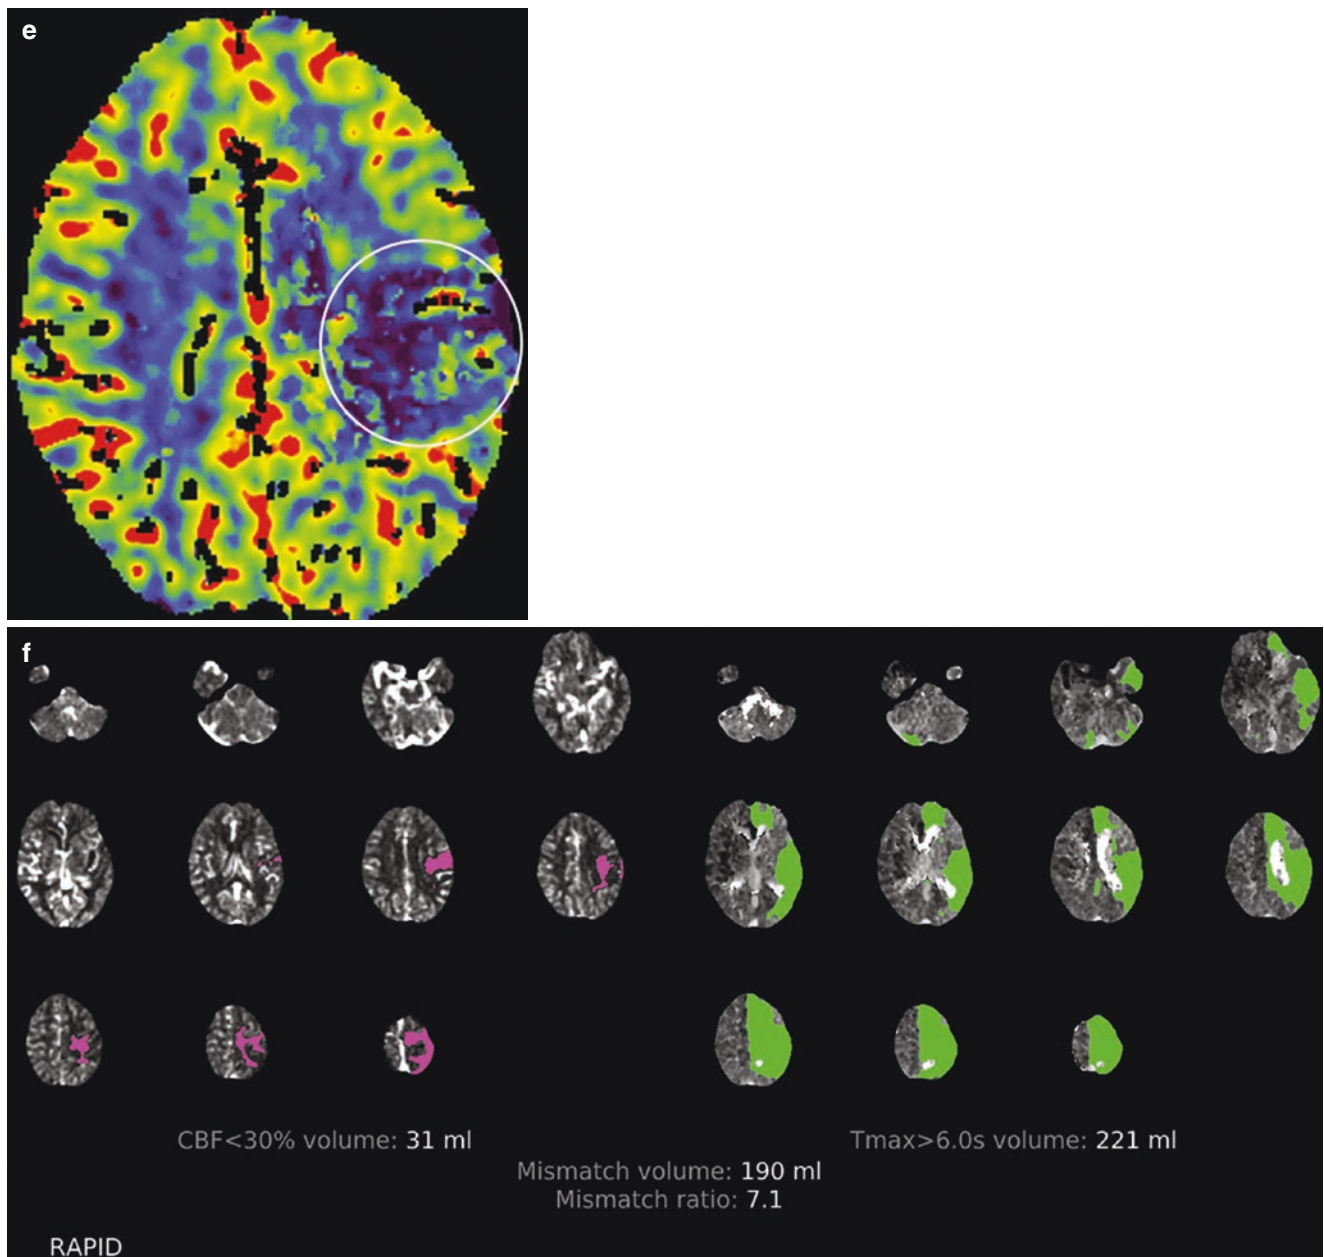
CTP overestimation of core infarction volume in patient with early reperfusion. Patient with history of atrial fibrillation presents with sudden-onset right-sided weakness. NCCT is unremarkable (not shown). (a), Axial CTA MIP shows occlusion of proximal M2 segment of left MCA. This is a “M1 like” M2 occlusion since both anterior and posterior division are involved. (b), Sagittal CTA MIP shows additional occlusion of left ACA A2 segment. CTP color images show prolongation of TTD (c) and decreased CBF (d) in the left MCA and ACA territories. (e), The corona radiata in the ACA/MCA border zone and lateral frontal cortex demonstrate decreased CBV (e) (circle) suspicious
